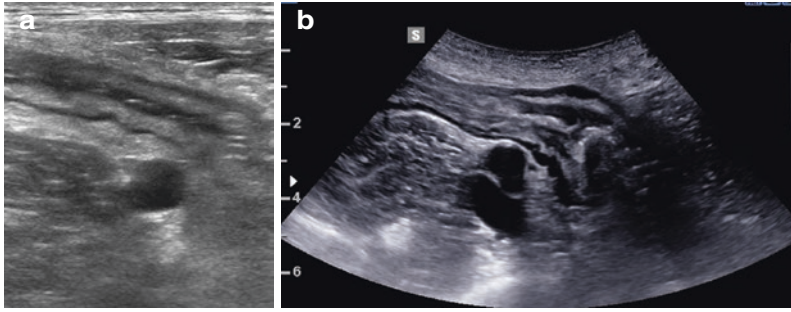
(a) A demonstrates echostratification, in a thickened terminal ileum draping over the psoas muscle. The iliac artery is evident medial to the psoas muscle. There are three commonly visible layers on intestinal ultrasound, demonstrated here from the exterior of bowel wall to the interior: the hypoechoic muscularis propria, the most prominent muscle layer; the hyperechoic submucosal layer (often the most prominent layer, expanded in chronic disease states); the inner hypoechoic demonstrates the muscularis mucosae, the dark line evident just below the hyperechoic mucosa which is often bright with luminal air. Returning to the outer layer again, the serosa, can be seen as a very thin hyperechoic reflection on the margin of the muscularis propria. (b) Axial depiction of terminal ileum, demonstrating normal wall layers or echostratification, again from lumen to serosa including the muscularis mucosae, submucosa and muscularis propria, characterizing three typical wall layers consistently seen on ultrasound
